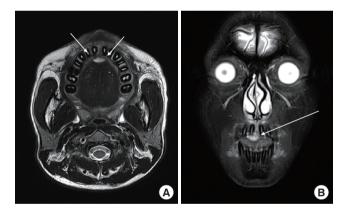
Magnetic resonance imaging reveals a $1.9 \times 1.6 \times 1.0$ cm tadpole-shaped (arrows), T2-high-signal-intensity lesion in the midline hard palate, suggestive of a minor salivary gland tumor. (A) Axial view. (B) Coronal view.
